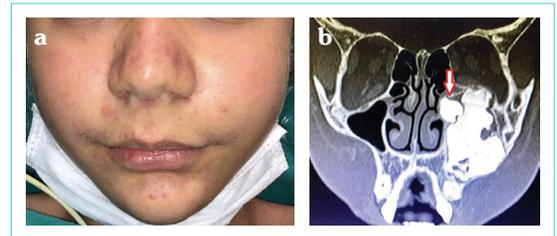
(a) Asymmetry is observed in the left upper jaw. (b) Image of computed tomography scan shows mass that completely fills the maxillary sinus and the presence of an ectopic tooth
